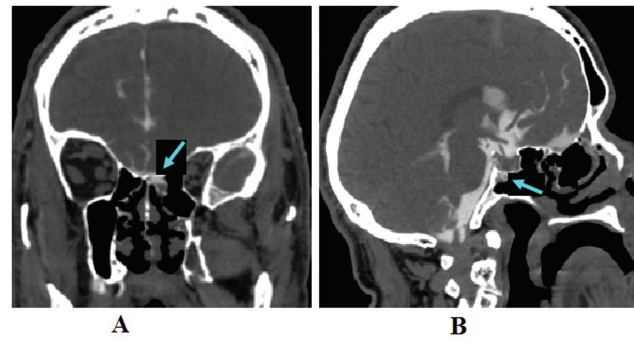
CT cisternography. Show two defects at different sites of skull base; one at the bottom of Turkish saddle (B), Posterior ethmoid bone cells from the rightside (A). Defects are shown by arrows.
